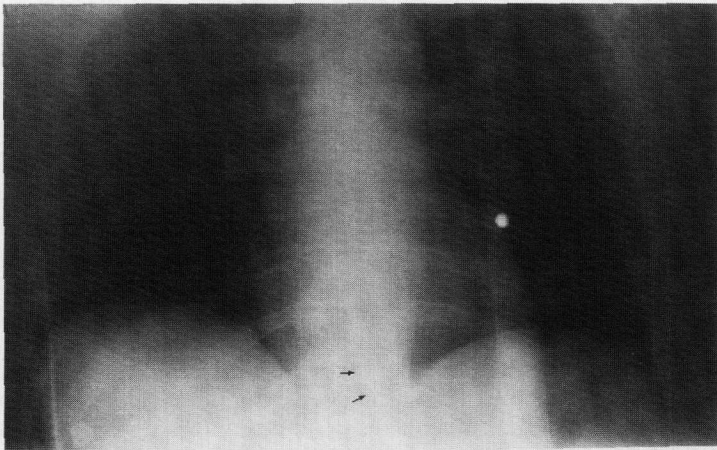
Antemortem anteroposterior radiograph of the chest. (Arrows on the lower part of the photograph at the level of the 11th thoracic vertebra point to two metallic surgical staples.)
